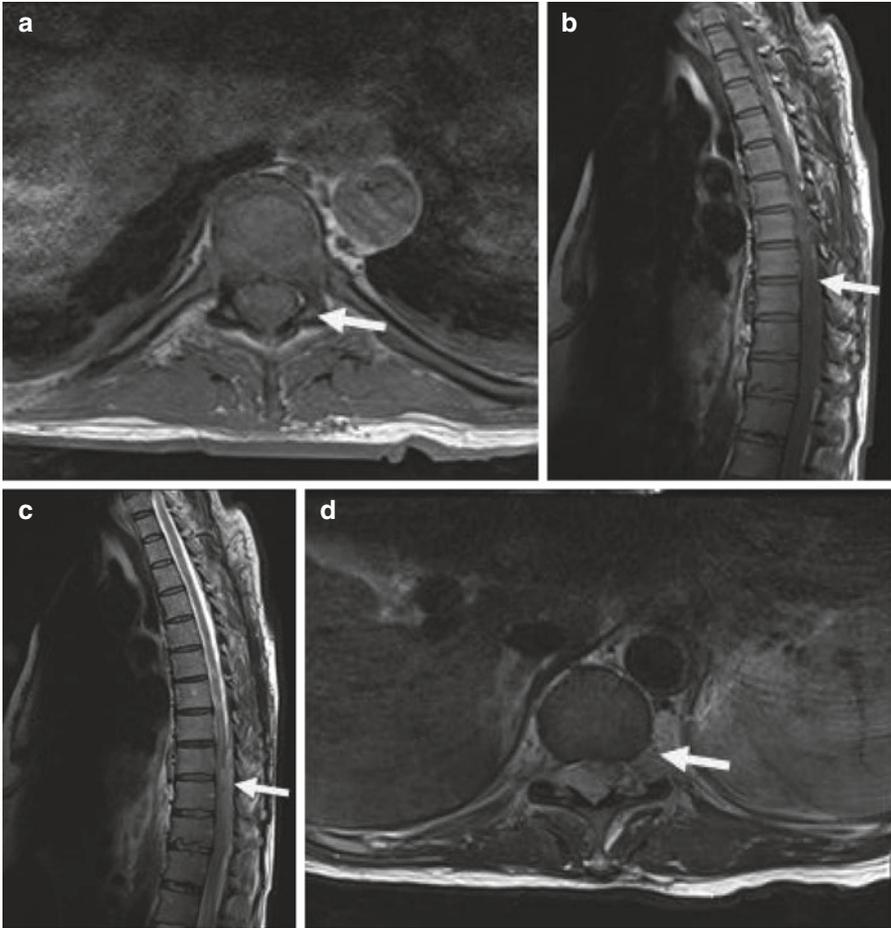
T1 and T2 MR image of the thoracic spine. (a) T1-weighted MR image of the thoracic spine in the *axial* view. (b) T1-weighted MR image of the thoracic spine in the *sagittal* view. (c) T2-weighted MR image of the thoracic spine in the *sagittal* view. (d) T2-weighted MR image of the thoracic spine in the *axial* view
